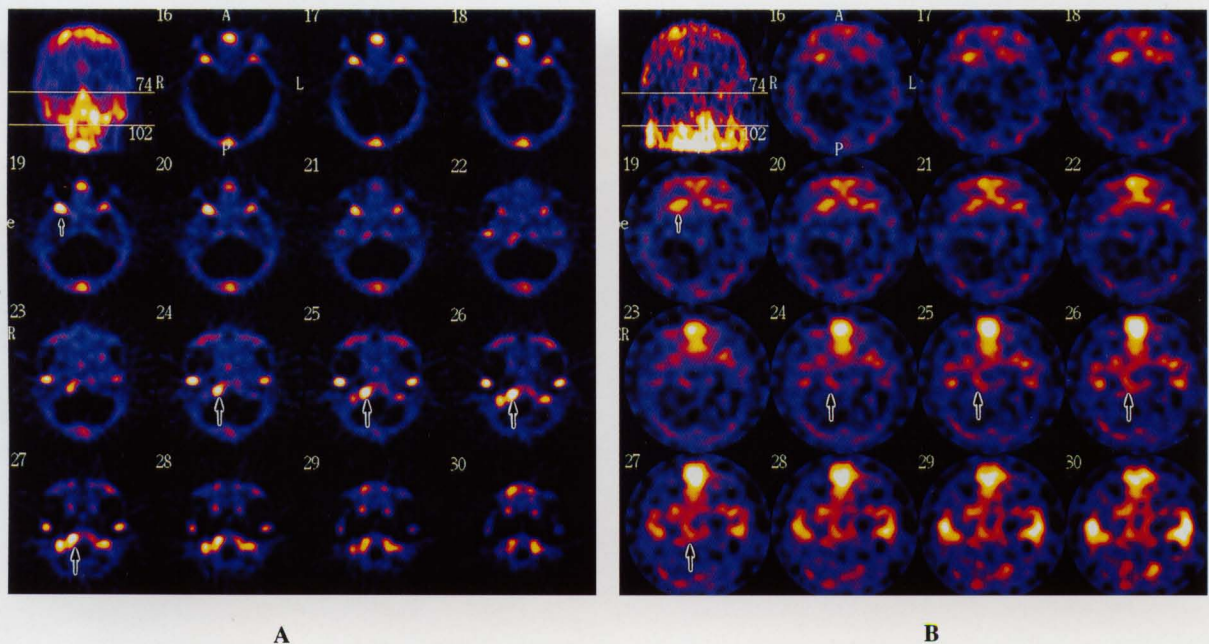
Dual-isotope SPECT of the skull base. ^{99m}Tc-HMDP bone SPECT (A) and ²⁰¹Tl tumor SPECT (B) are shown. The tomographic level shown for the two isotopes is the same. A lesion with intense ^{99m}Tc-HMDP uptake and ²⁰¹Tl delayed retention is observed in the area of the right hypoglossal canal (arrow). The ²⁰¹Tl-positive lesion is elongated parallel to the long axis of the hypoglossal canal, indicating that the metastatic lesion spreads into the canal with direct involvement of the nerve (arrow). In the right middle cranial fossa, the sphenoid bone shows intense uptake of the tracers (small arrow) representing a suspicion of asymptomatic metastasis not shown by CT or MRI.
